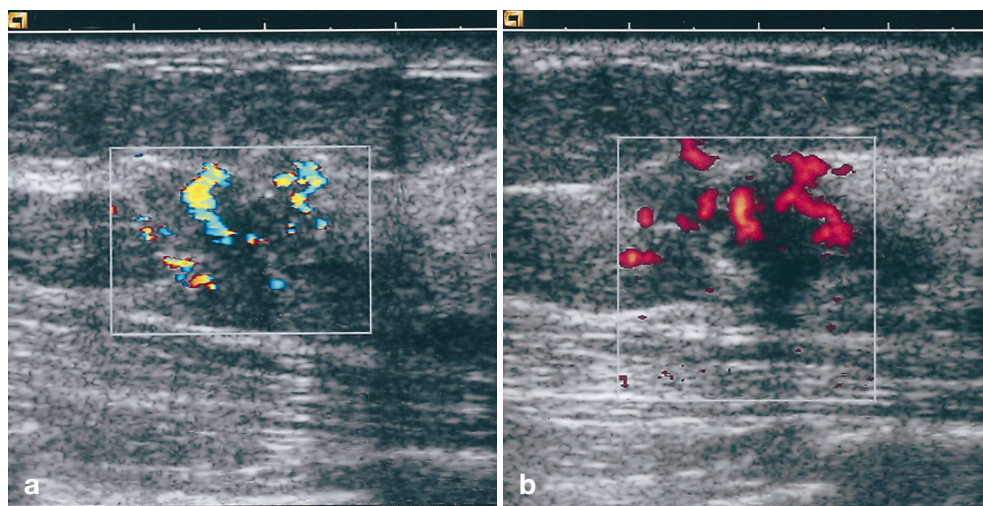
a, b. Invasive ductal breast carcinoma. Colour Doppler shows irregularly arranged vessels. a Colours encode flow velocities and flow directions but may be flawed by aliasing if sensitive settings are used. b With amplitude encoding Doppler, flow velocities are neglected, the image only showing local Doppler signal amplitudes, independent of flow velocity or vessel orientation. Whether conventional or amplitude encoding colour Doppler is more sensitive appears to be different from platform to platform
